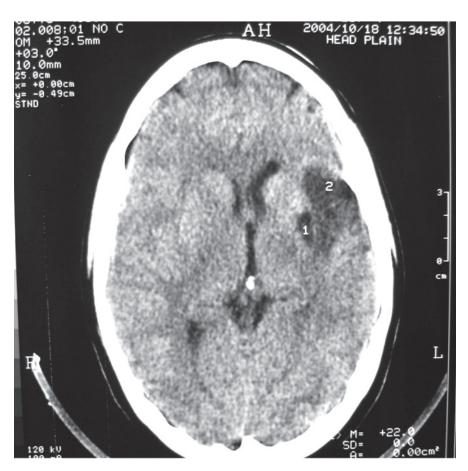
Brain CT scan of Patient 1 showing infarcts in left opercular and subopercular region
